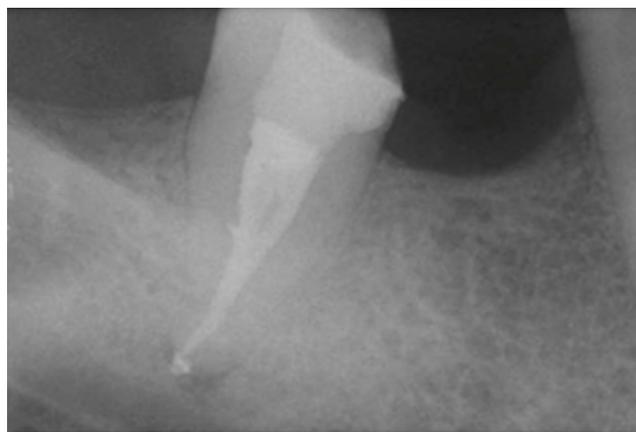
Post-operative radiograph of 4.7. Obturation with thermo-plasticized guttapercha after activation and heating of irrigants: a complex endodontic anatomy is shown.
